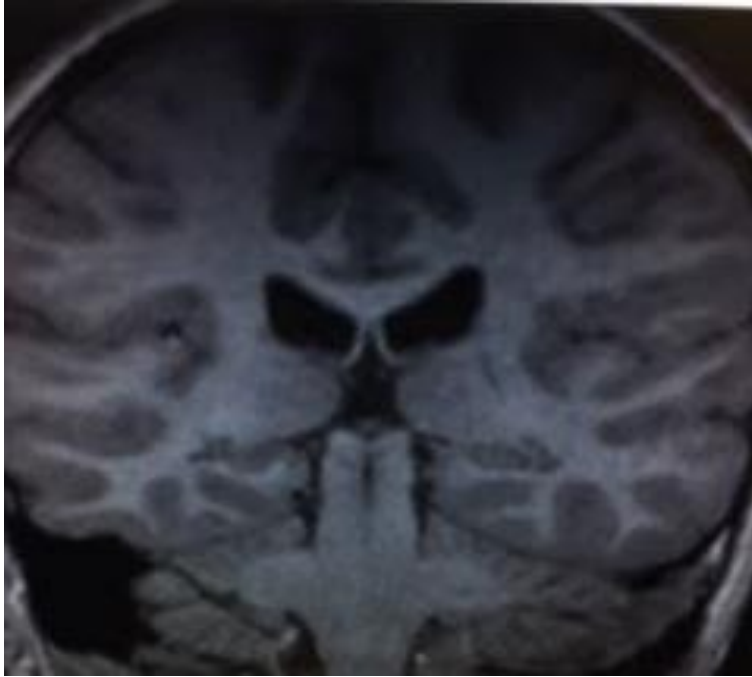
Pulvinar of thalamus still in view; MRI scan; coronal view
